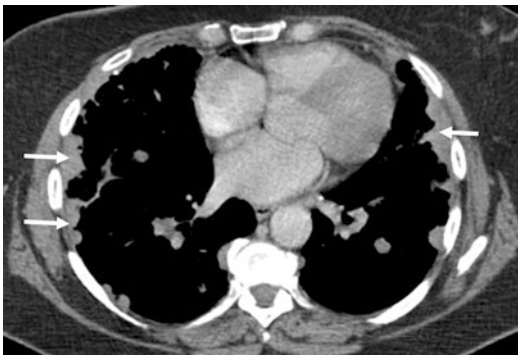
Nodular pleural tuberculosis in a young woman. Axial contrast-enhanced CT image shows multiple areas of nodular pleural tuberculosis (arrows). There is no effusion. The diagnosis was confirmed by surgical biopsy
